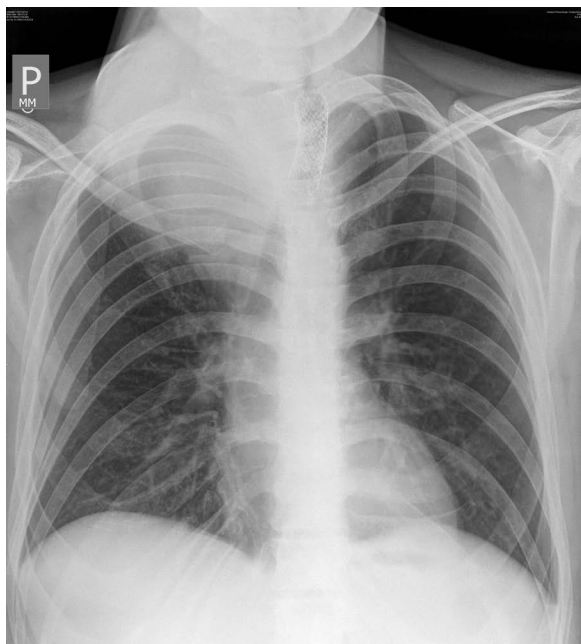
Control X-ray of the ribcage in the PA view — after placing a self-expandable stent in the trachea
